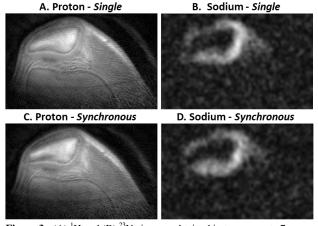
(A) ¹H and (B) ²³Na images obtained in two separate 7 minute single-nuclear MRI scans. (C) ¹H and (D) ²³Na images synchronously obtained in a single 7 minute dnMRI acquisition.
